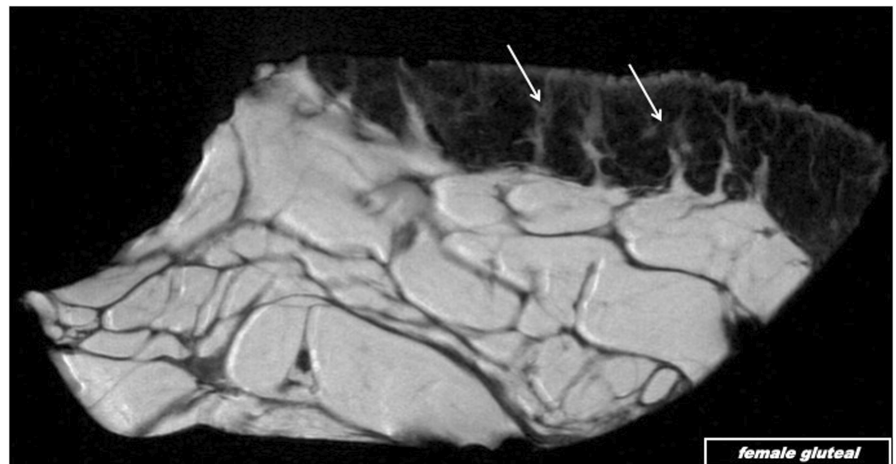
7T-MRI of adipose papilla showed the three functional subunits: basement that originates from superficial layer of gluteal femoral area, neck that protrude in dermis and head (A). Heads of adipose papilla were characterized by protrusion with a signal intensity lower than fat and higher than collagen (B, white arrows).
